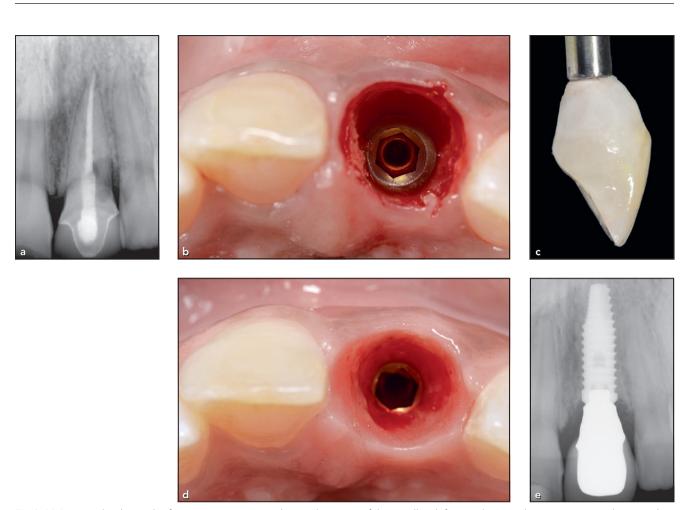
(a) Periapical radiograph of a patient requiring implant replacement of the maxillary left central incisor due to a resorption lesion in the distal aspect of the tooth. (b) The implant was placed toward the palatal aspect of the extraction socket. (c) The provisional restoration was constructed with convex facial subcritical contour to support the existing tissues with palatal implant placement. (d) The labial peri-implant soft tissues need support after healing to maintain the free gingival margin and zenith in the correct position. (e) The final radiograph shows the gradual interproximal supportive contours of the metal-ceramic screw-retained crown restoration.
